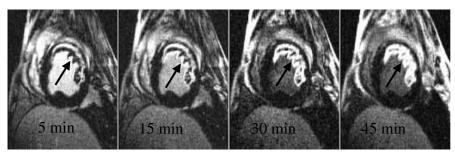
The no-reflow phenomenon revealed by contrast enhanced magnetic resonance imaging. The no-reflow zones are almost always completely surrounded by larger regions of hyper-enhancement and, importantly, slowly become hyper-enhanced as repeated images are acquired at the same location over time. This can be explained by microvascular damage which impedes penetration of the magnetic resonance imaging contrast agent into the core of the infarct. Since flow in these regions is low but not zero, these regions appear dark initially but as contrast accumulates they slowly become hyper-enhanced. Labels refer to time after administration of contrast media.
